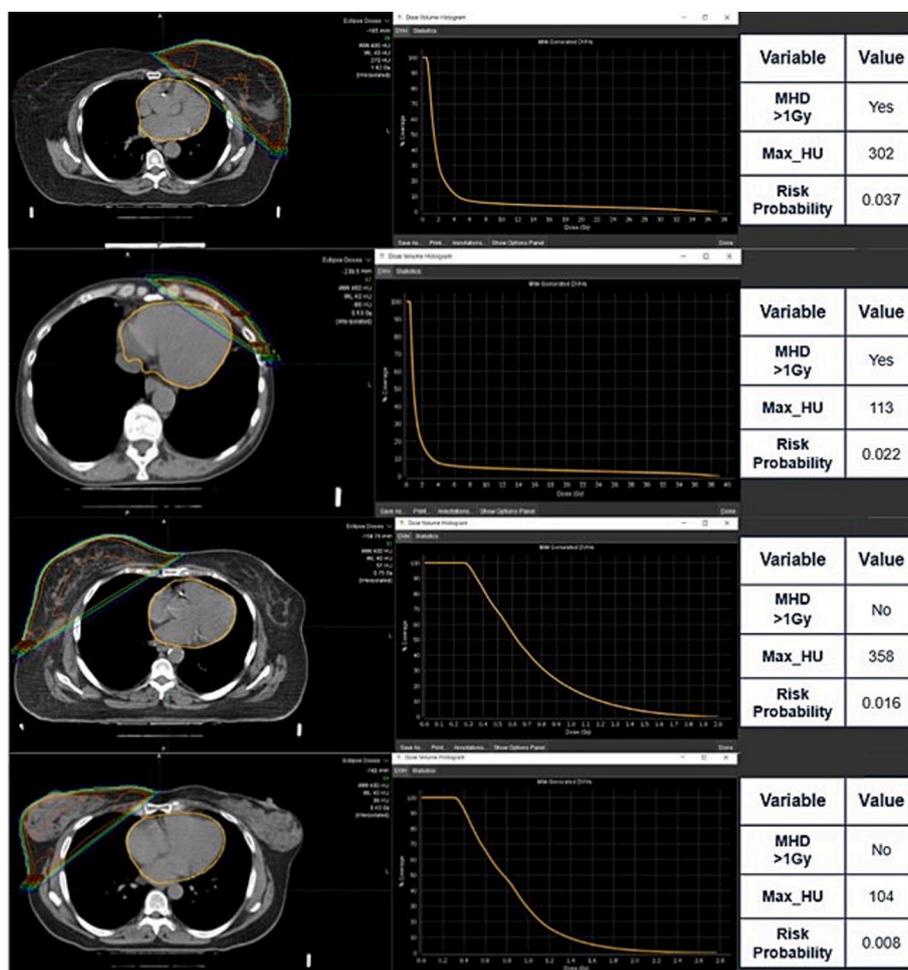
As an example, four patients with different cardiac risk and the same age (median value for the population, 62 years) are shown including the dose distribution on planning CT, heart DVH and the Max_HU value.
